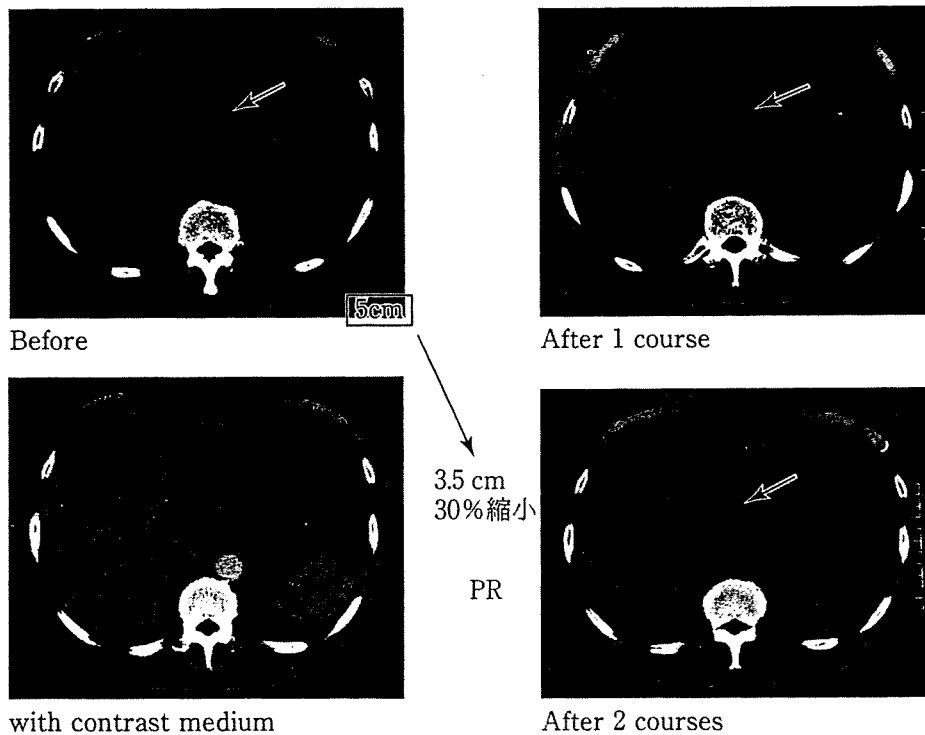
CT による bulky N2 の評価
